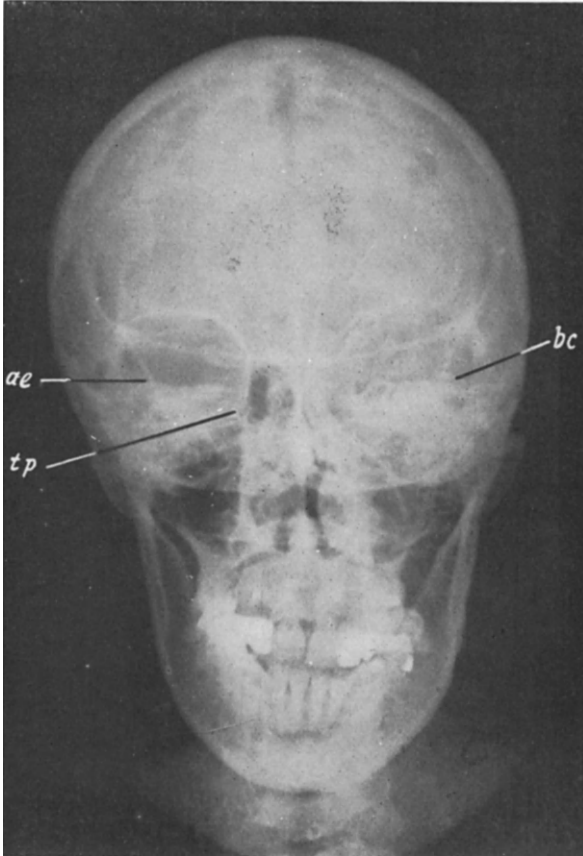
B. X-RAY PICTURE OF FRACTURE OF APEX OF PYRAMID
